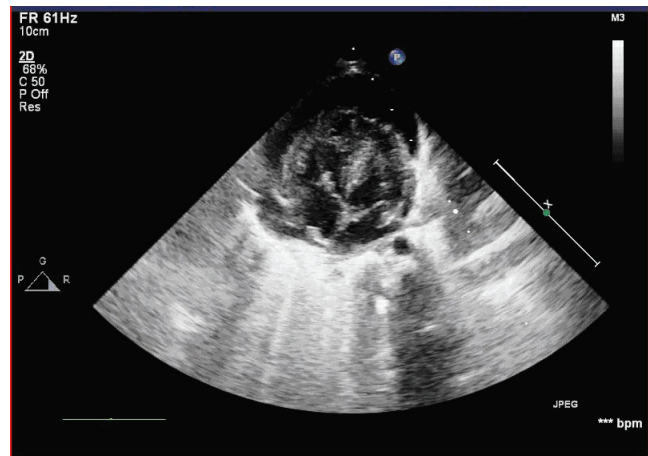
Echocardiogram showing a large pericardial effusion
